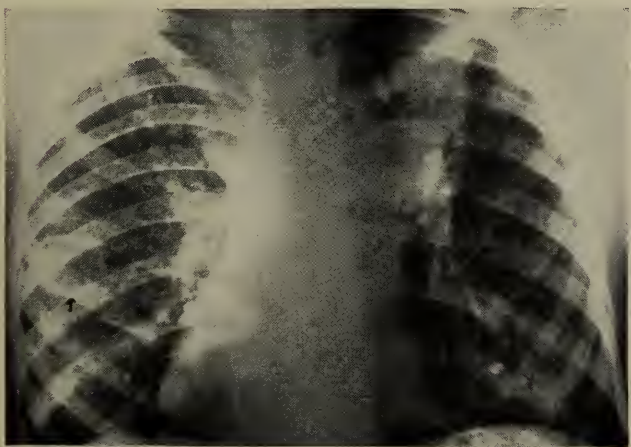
X-ray of chest indicating dextroposition of the heart, thin-walled tuberculous cavity in right lung, and soft follicular type spread in both lung fields. The left upper lobe also has a fibrocalcific lesion with partial atelectasis.
